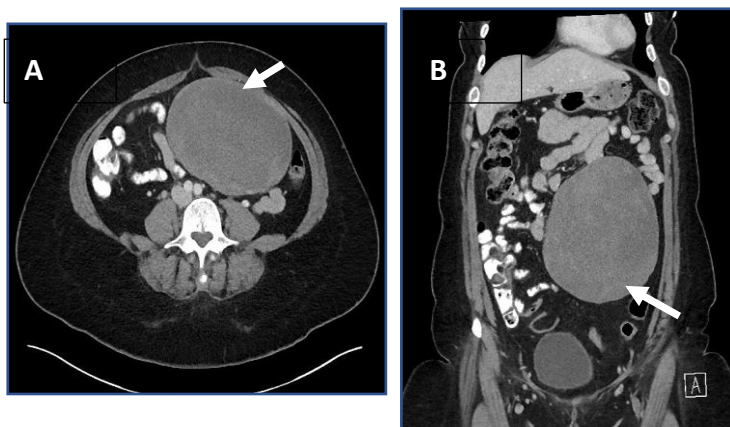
CT Abdomen A. Axial & B Sagittal showing a large intra-abdominal mass of size 25x15x10 cm (white arrows)
